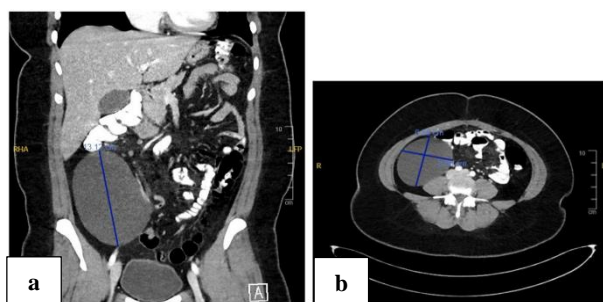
CT abdomen in (a) coronal and (b) axial planes that show the location of the mesenteric cyst in the RLQ of the abdomen.
